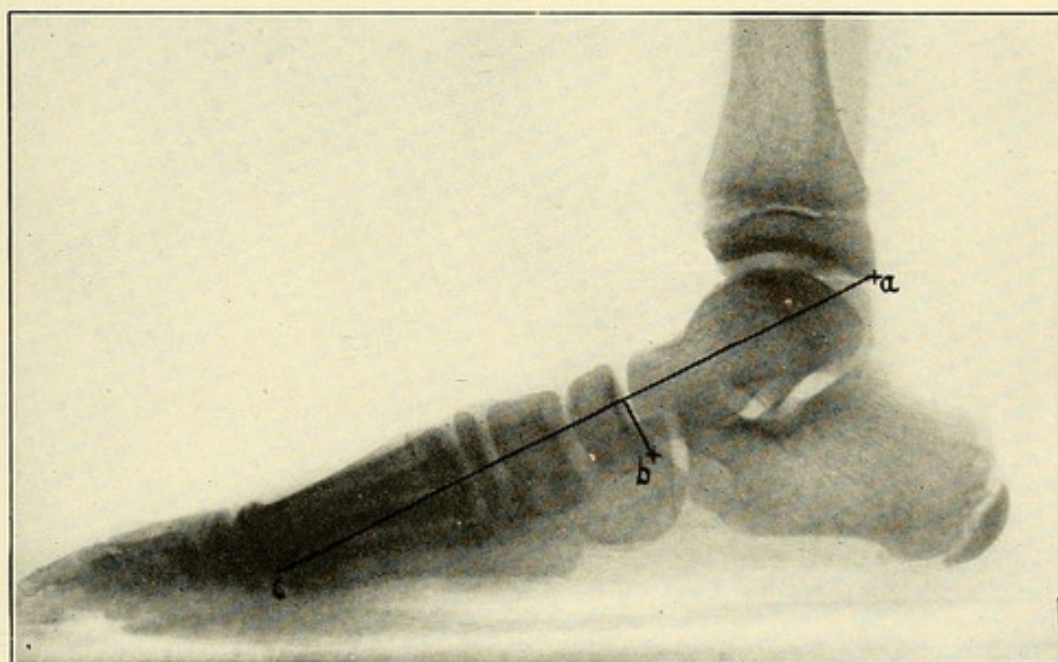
Roentgen picture of same foot with weight-bearing. Same points marked. Note increased distance of *b* from connecting line.
